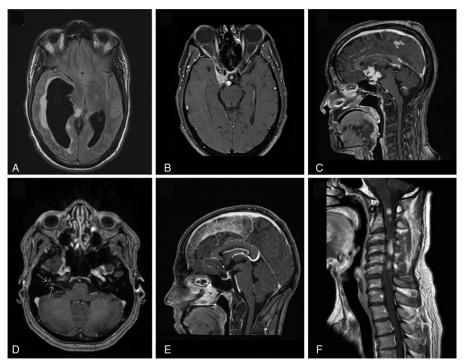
MRI results of patients with neurosarcoidosis. (A) Hydrocephalus because of an obstructive multicystic mass. (B) Meningeal enhancement and thickening of the right cavernous sinus in a patient with a third nerve palsy. (C) Leptomeningeal nodular enhancing lesions in a patient with cognitive decline and an abnormal gait. (D) Enhancement and thickening of the facial nerve (arrow) in a patient with facial nerve palsy. (E) Leptomeningeal and dural enhancement in a patient with chronic meningitis. (F) Enhancing lesions of the spinal cord in a patient with sensory loss and paresis of the left arm and leg.
